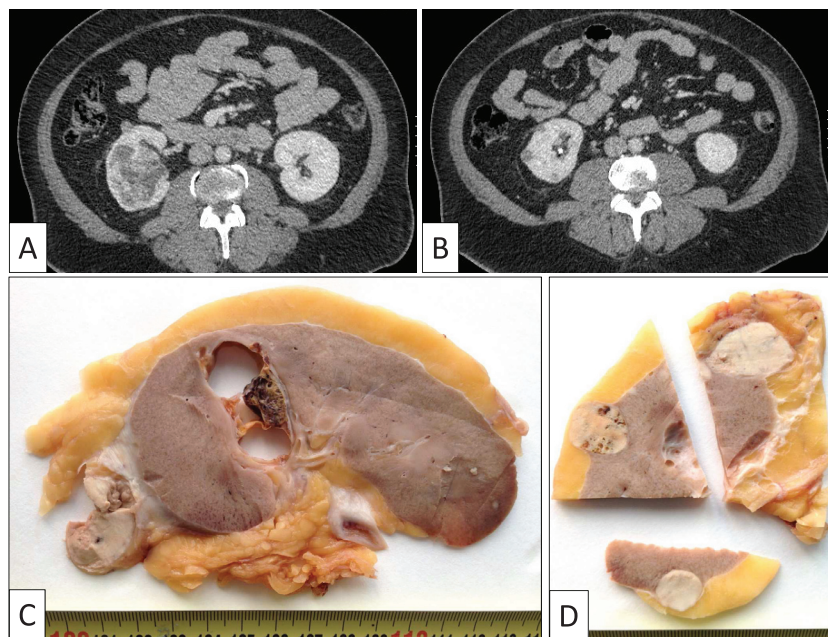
CT scans show multiple tumors in the right kidney (A and B). Gross examination displays a yellowish central tumor with solid-cystic areas corresponding to a clear cell renal cell carcinoma (C) and four peripheral whitish tumors and several intrarenal micronodules corresponding to biphasic squamoid alveolar renal cell carcinomas (C and D).
